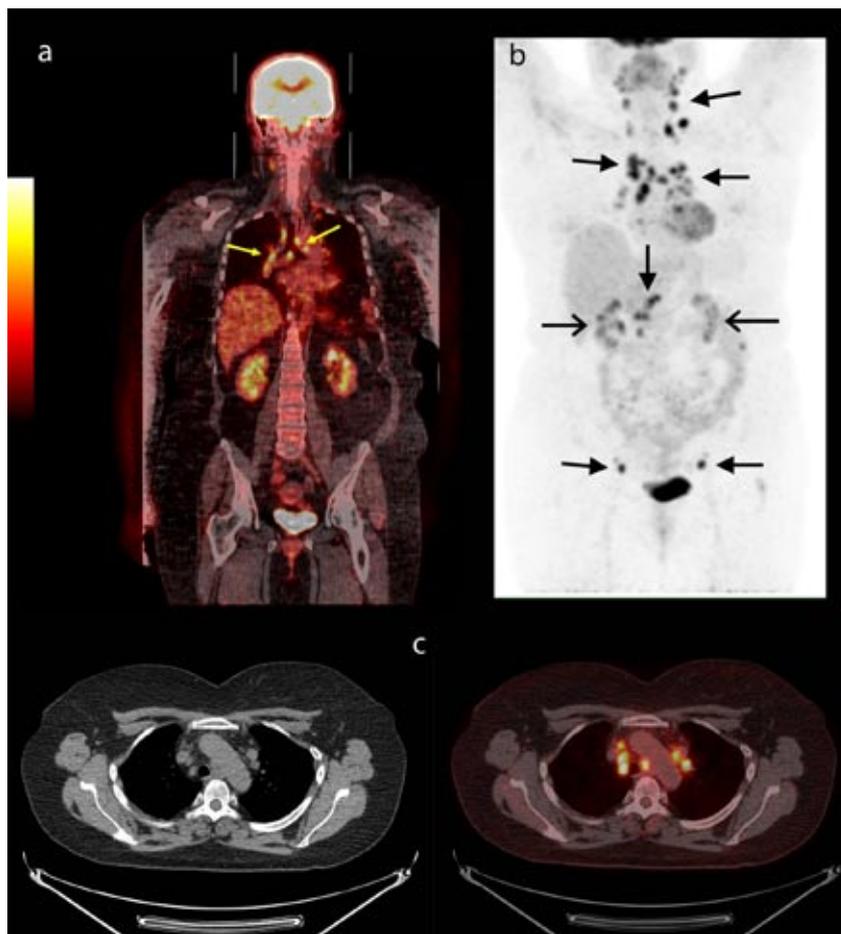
Integrated fluorodeoxyglucose positron emission tomography-computerised tomography can identify biopsy sites and extrapulmonary disease. In this patient with sarcoidosis, the technique identified active disease, the extent of which was not apparent on computed tomography imaging alone. Panel (a) is a fusion image showing increased uptake in mediastinal nodes (arrows); panel (b) is a maximum intensity projection image showing increased uptake in neck, mediastinal, coeliac, and inguinal nodes (closed arrows) and physiological uptake in kidneys (open arrows); panel (c) is an axial computed tomography and fused image at the level of the aortic arch showing increased fluorodeoxyglucose uptake in prevascular, left paratracheal, and right paratracheal nodes, none of which are enlarged by conventional size criteria
